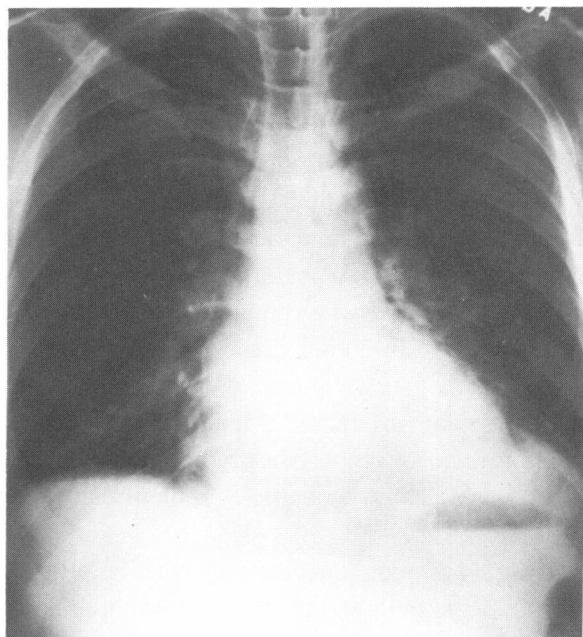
a, b*. This 32-year-old man presented to the Emergency Room following an episode of violent vomiting. The preliminary chest radiograph reveals pneumomediastinum, an increased density behind the heart with obliteration of the left hemidiaphragm, and a left subpulmonic effusion (Figure 4*a*). The overpenetrated chest radiograph (Figure 4*b*) better demonstrates the pneumomediastinum as evidenced by linear gas shadows within the mediastinum (white arrowheads).
